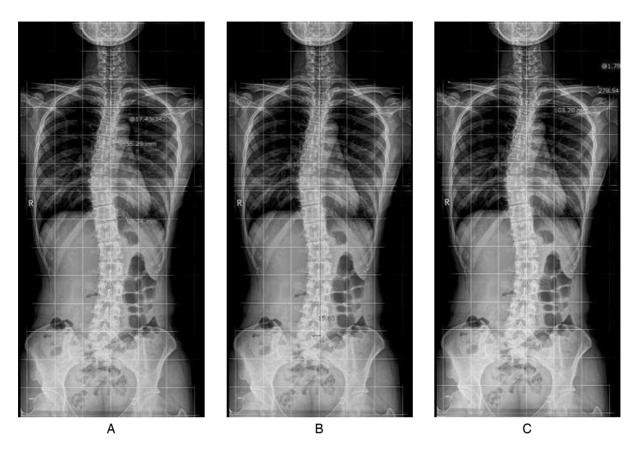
Whole spine x-ray after treatment. (A) Cobbs angle, 17°, is obtained by measuring the maximal angle from the superior endplate of T6 vertebra to the inferior endplate of the T11 vertebra. (B) Coronal balance, negative 1.6 cm, is measured as distance between C7 plumb line and central sacral vertical line. (C) Clavicle angle, negative 1.8°, is formed by the intersection of a horizontal line and the tangential line connecting the highest two points of each clavicle.
